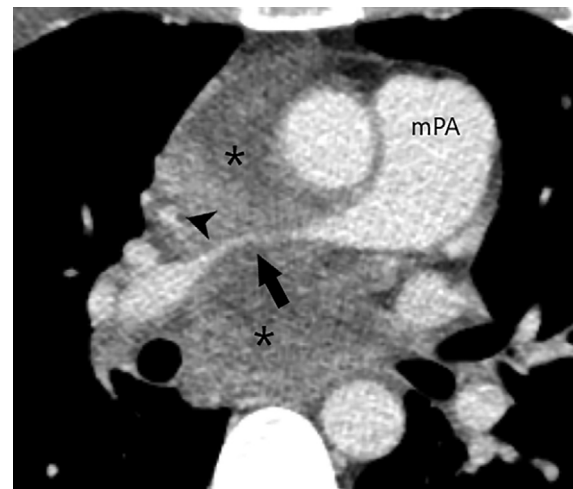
CT pulmonary angiography, multiplanar reformatted reconstruction, oblique plane - the mediastinal mass can be seen (asterisks), determining compression of the RPA (arrow); the stenotic SVC can also be appreciated (arrowhead).
